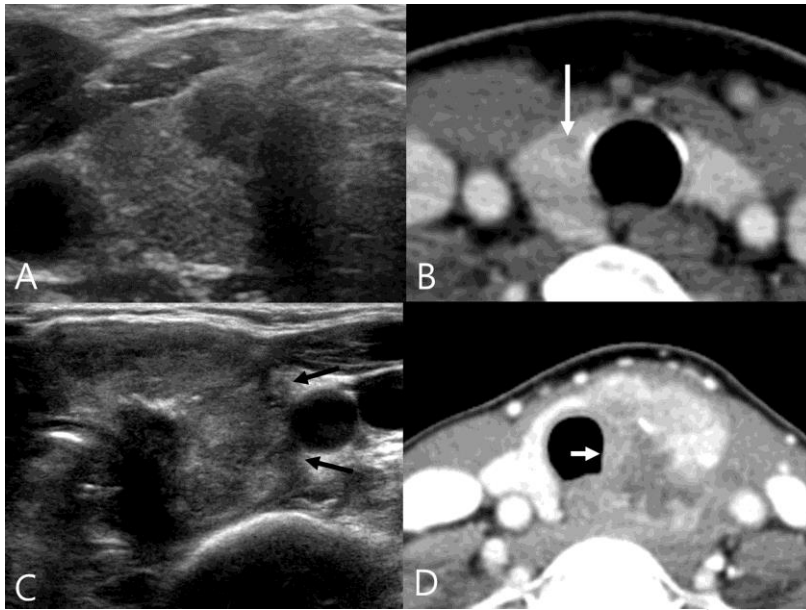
Extrathyroidal extension (tracheal invasion). A, B. Minimal invasion of the peritracheal tissue. The US image shows a nodule abutting the trachea at an obtuse angle (A). The CT image shows no intraluminal tumor invasion (B, arrow). Surgery: Extrathyroidal tumor invasion of the tracheal adventitia (pT4a). Diagnosis: Papillary carcinoma; C, D. Intraluminal tumor invasion of the trachea. The US image shows a large nodule encircling the trachea and a suspicious gross extrathyroidal extension (C, arrows). The CT image reveals an infiltrative large tumor with the intraluminal involvement of the trachea (D, arrow). Surgery: Extensive intraluminal tracheal invasion (pT4a). Diagnosis: Papillary carcinoma.
